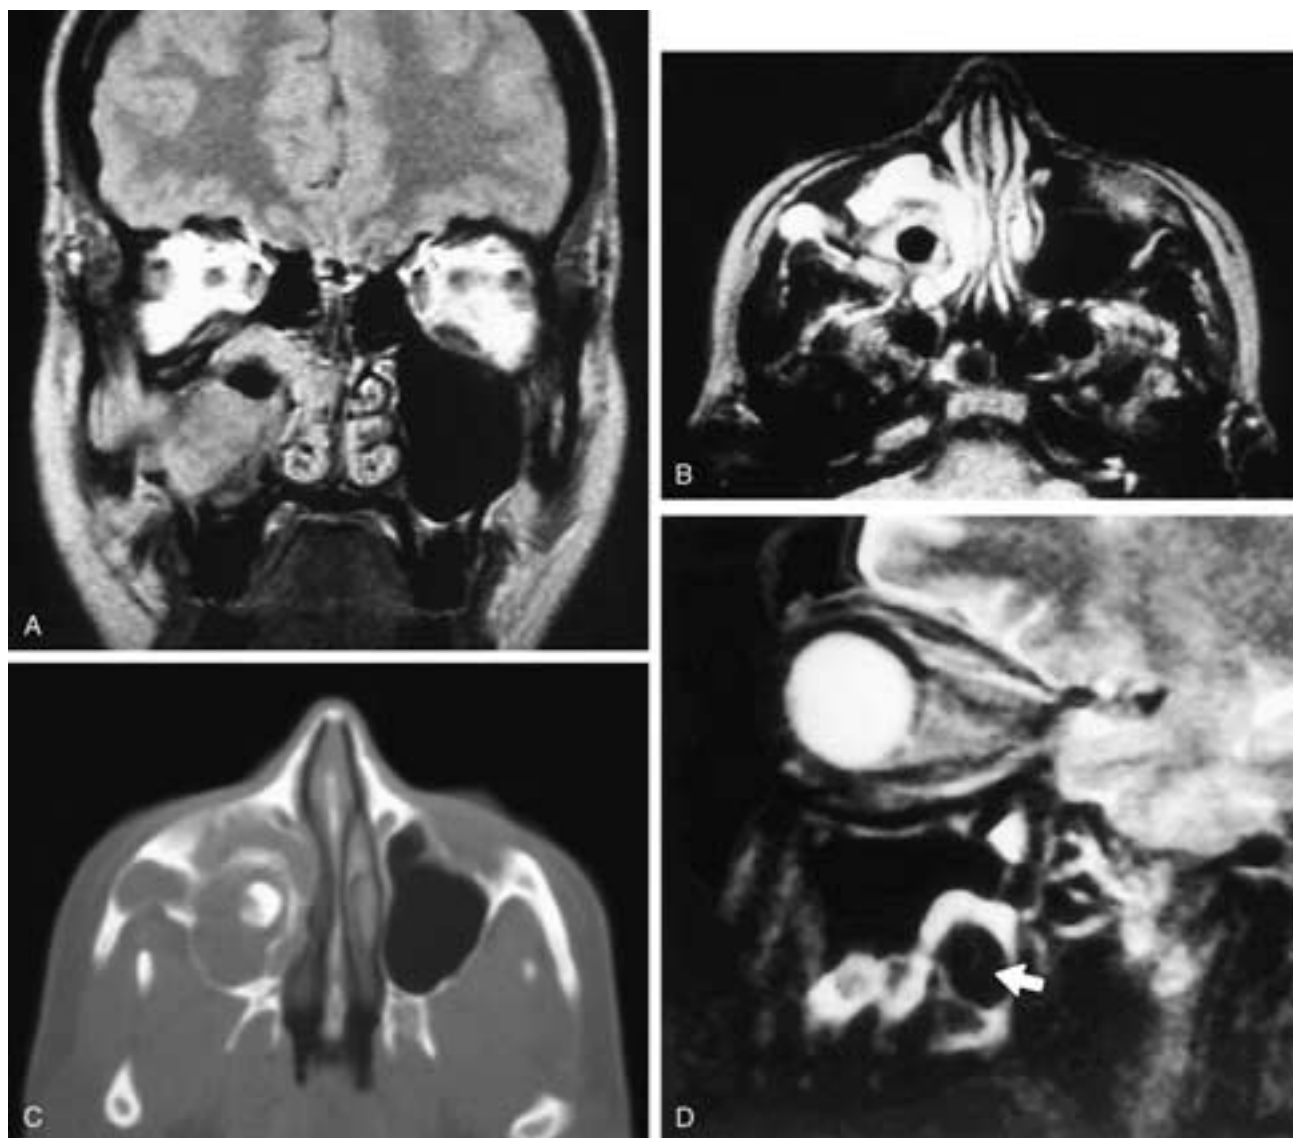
Coronal T1-weighted (A) and axial T2-weighted (B) MR images show a slightly expanded right maxillary sinus filled for the most part with inflammatory-type material. Within the sinus is an area of signal void. This could have been residual sinus air, desiccated secretions, a mycetoma, or a sinolith. An axial CT scan (C) shows that it was a tooth in a dentigerous cyst. A sagittal T2-weighted (D) image on another patient shows an area of signal void (arrow) just under the floor of the maxillary sinus. This patient had an undescended molar tooth.
